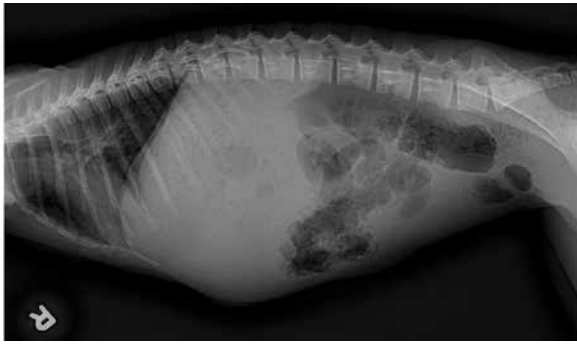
Case 1. Radiograph, right lateral, abdomen. Generalized loss of abdominal serosal detail, severe hepatomegaly, and distended, gas-filled intestines.
